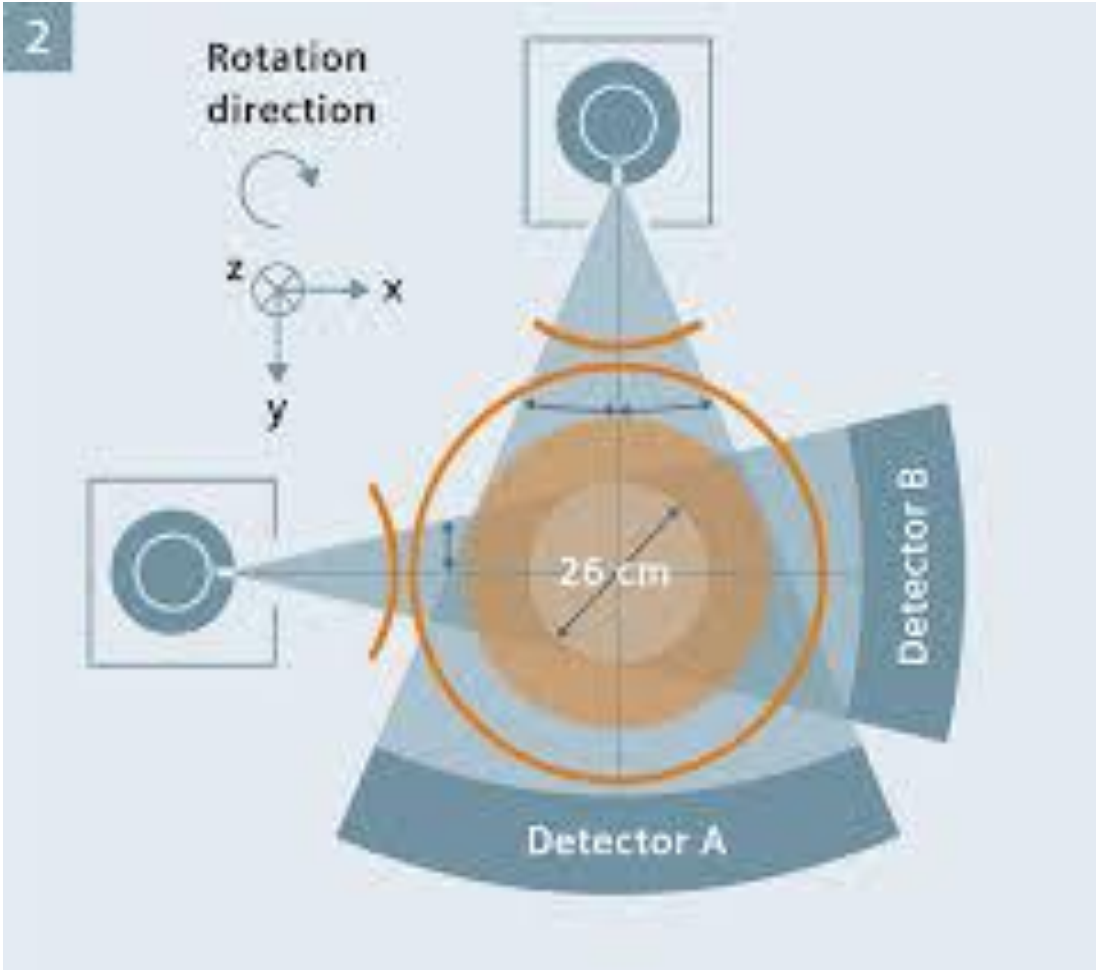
Prototype of seventh generation CT scanner (Seeram, 2009).*
